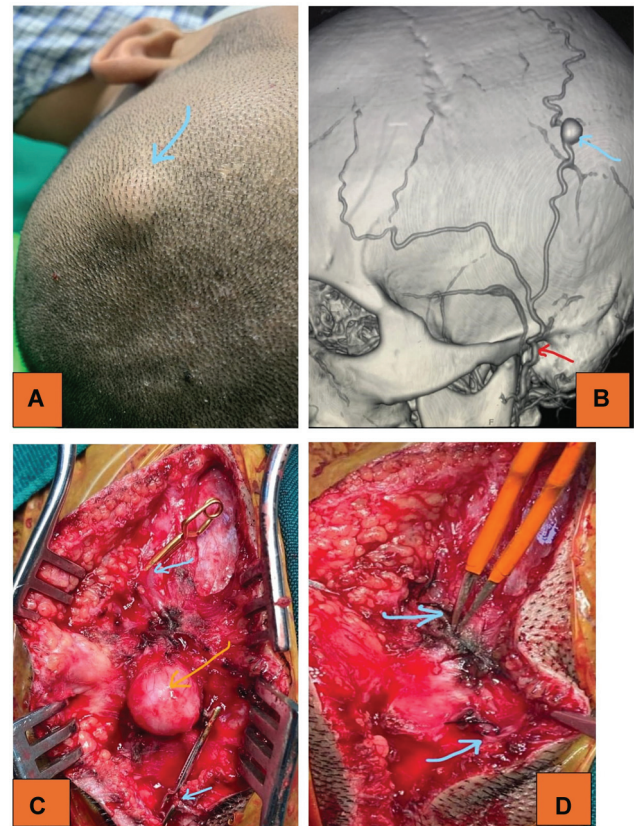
(A) Subcutaneous swelling in the left temporal region. (B) Computed tomography (CT) angiography showing an aneurysm arising from the posterior branch of the superficial temporal artery (STA). (C) Arrows showing the aneurysm sac with both proximal and distal control. (D) Aneurysm is excised along with ligation of both proximal and distal segment of the STA.
